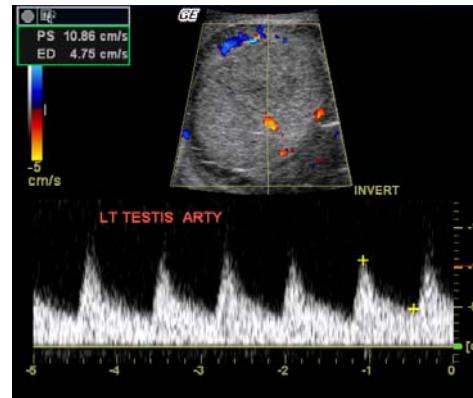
Color Doppler arterial waveforms revealing blood flow to the left testicle.
